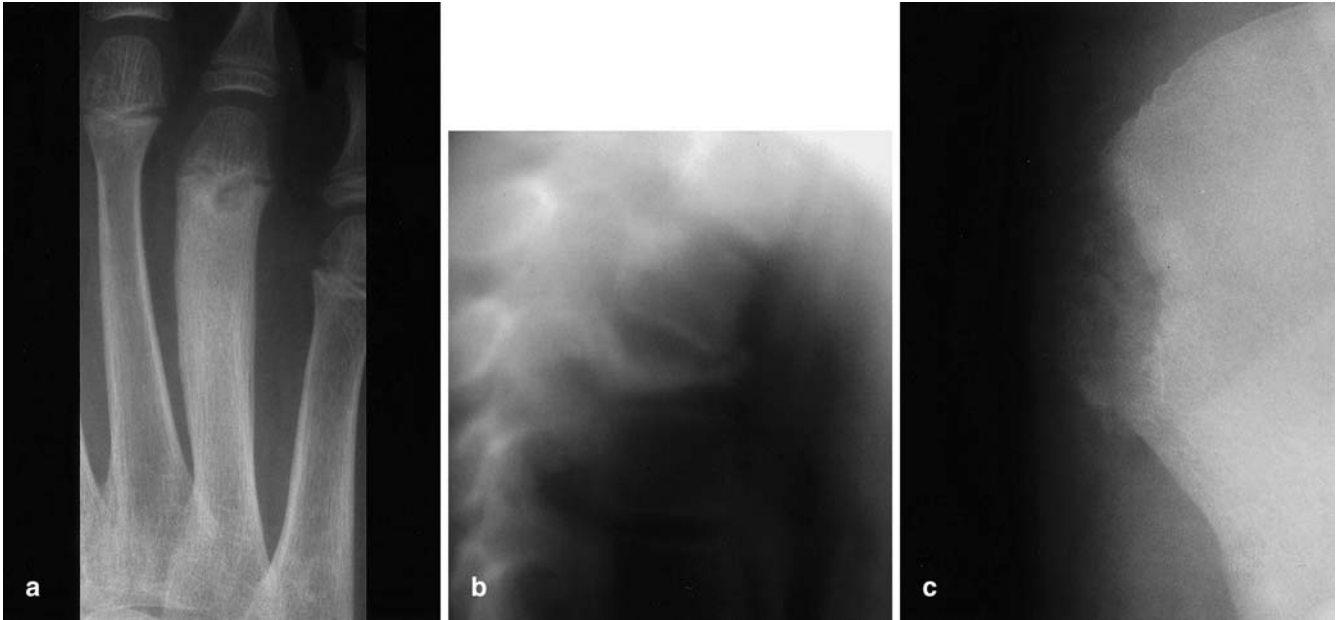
Chronic recurrent multifocal osteomyelitis (CRMO). This 10-year-old girl presented with pain in thoracic spine and the fore-foot. The radiograph of the 4th metatarsal (a) bone reveals classical signs of subacute or chronic osteomyelitis, comparable to Brodies's abscess. Conventional tomography of the upper thoracic spine (b) demonstrated a vertebra plana with flattening and sclerosis of the remaining parts of the vertebral body. In the iliac bone (c), additionally a radiolucency with a broad sclerotic rim is observed. Ten years later, at the age of 20, the patient developed another sclerotic focus in contralateral iliac bone (not shown)
